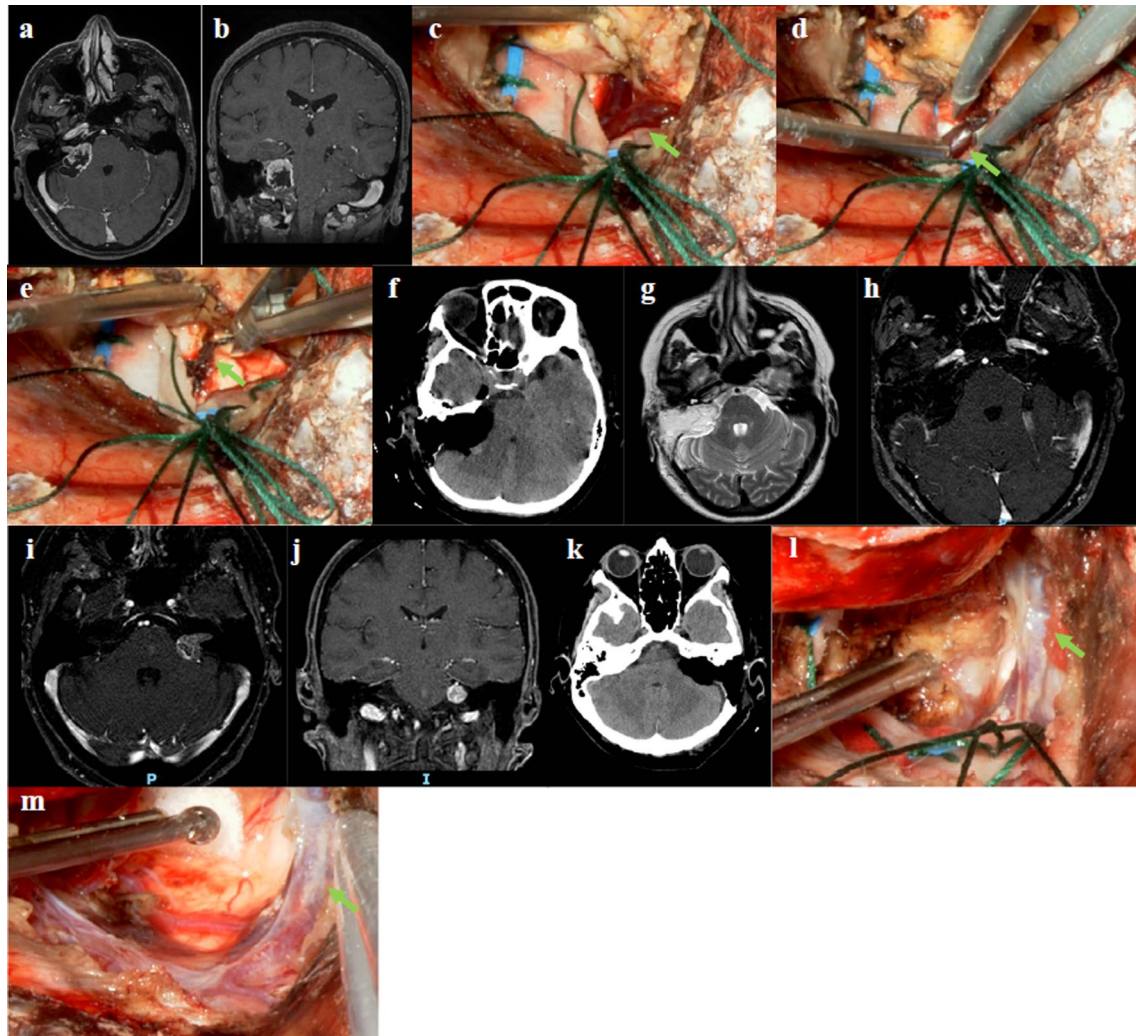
Case presentations. a–h A case of large vestibule schwannoma in a 57-year-old female complaining of tinnitus, facial numbness and dizziness with sacrifice of SPV during tumor resection. a, b Gadolinium-enhanced MR images before surgery. Axial (a) and coronal (b) images displayed a cystic tumor in the right CPA compressing the brainstem. The size of the tumor was measured as 3.51 cm × 1.72 cm × 1.93 cm. c Intraoperative visualization of SPV (green arrow) after retraction of the superoposterior pole of the tumor. d Coagulation of SPV. e Disconnection of SPV to facilitate further tumor dissection. f Postoperative CT scan displaying clear surgical cavity. g, h MR images 2 months after surgery. T2-weighted
